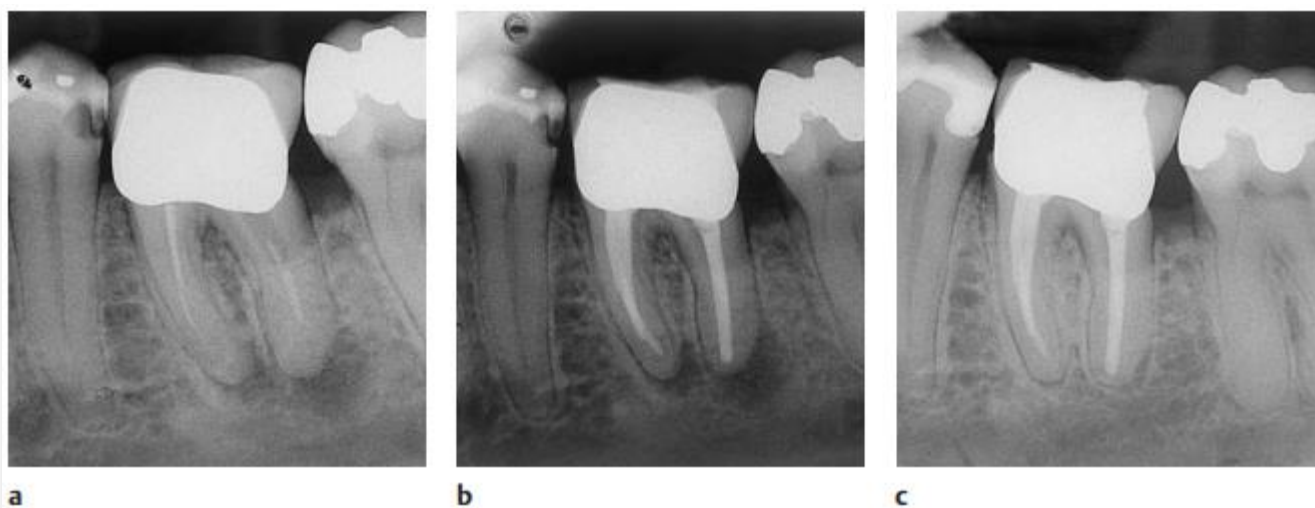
a.Radiograph of a mandibular molar with inadequate root filling and asymptomatic apical periodontitis, b.The tooth has been retreated conservatively through the crown, c.Complete periapical repair is evident at the 6-month control.
